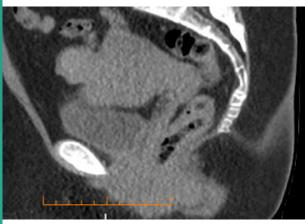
Mass on the sagittal view of patient's CT Abdomen Pelvis
